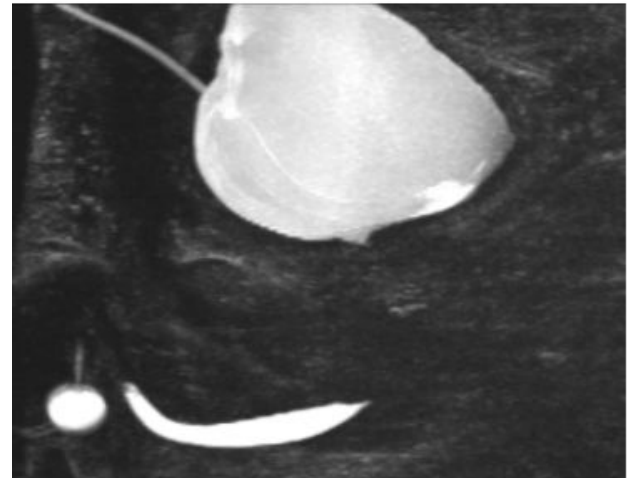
MRI with our protocol.
